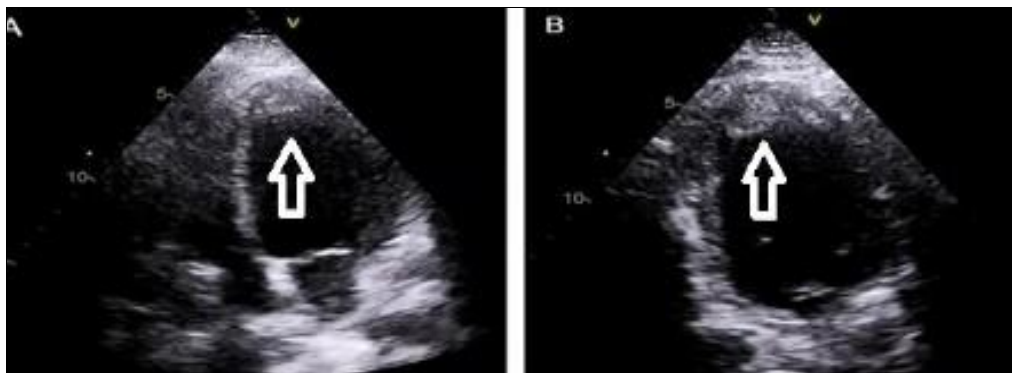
Echocardiography showing left ventricular apical thrombus shown by white arrow
